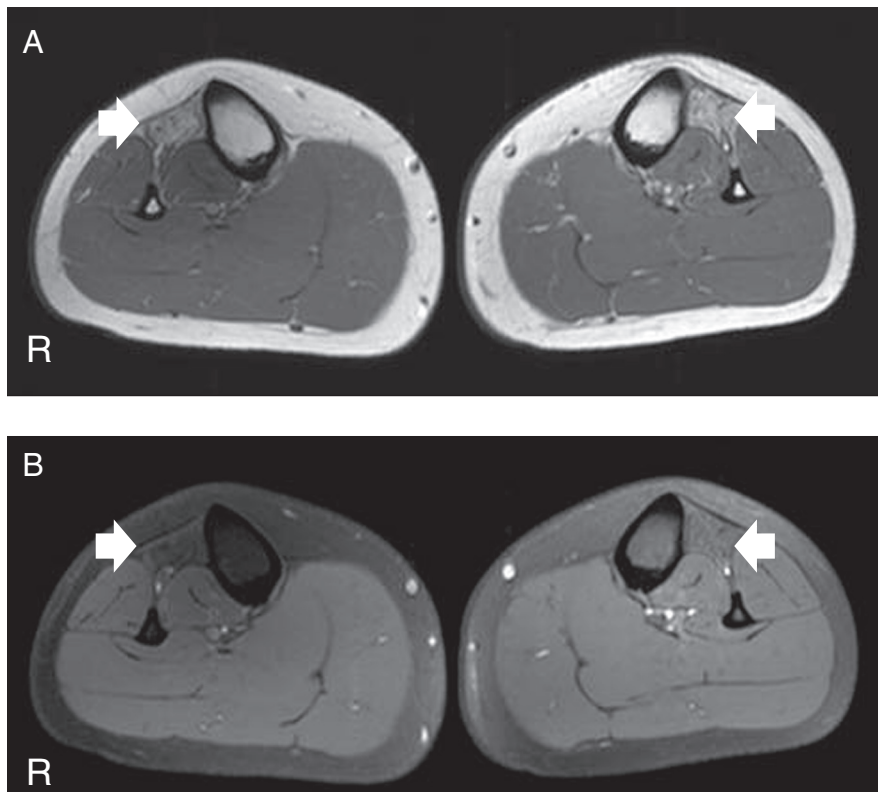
Magnetic resonance imaging of calf muscles (A and B). (A) T1-weighted axial image at calf level (TR, 730.34 ms; TE, 10 ms) shows high-intensity areas and atrophy in the bilateral tibialis anterior muscles, predominantly on the right (arrows). (B) T1-weighted SPIR axial image at calf level (TR, 627.05 ms; TE, 10 ms) shows no high-intensity areas in the bilateral tibialis anterior muscles (arrows).
